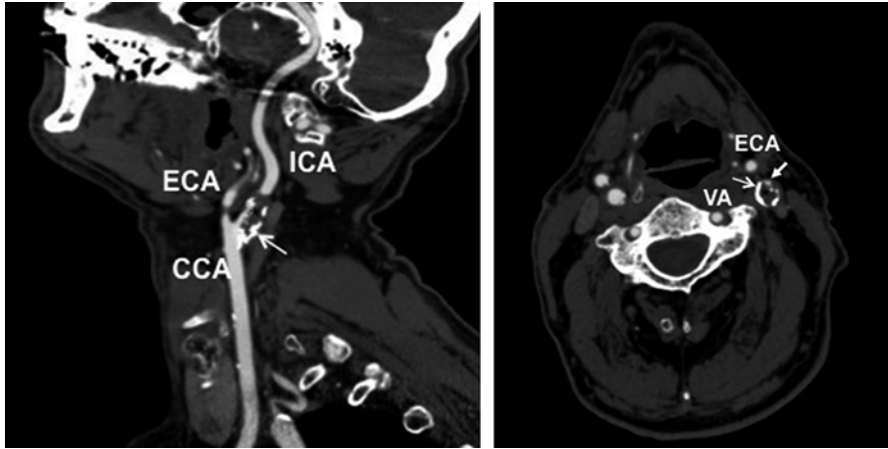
Atherosclerotic plaque in the left internal carotid artery, curved multiplanar reconstruction (MPR). Sagittal (*left*) and axial (*right*) CT angiography scans of the neck demonstrating >90 % narrowing of the internal carotid artery behind the common carotid artery bifurcation. Atherosclerotic plaque is represented by a hypodense area in the arterial lumen (*black star*), *open arrows* point to the plaque calcifications (the most apparent hyperdense part; on the axial scan forming a hyperdense rim). *White arrow* on the axial scan (*right*) shows the residual vascular lumen (diminished by mass of the plaque). CCA common carotid artery, ECA external carotid artery, ICA internal carotid artery, VA vertebral artery
